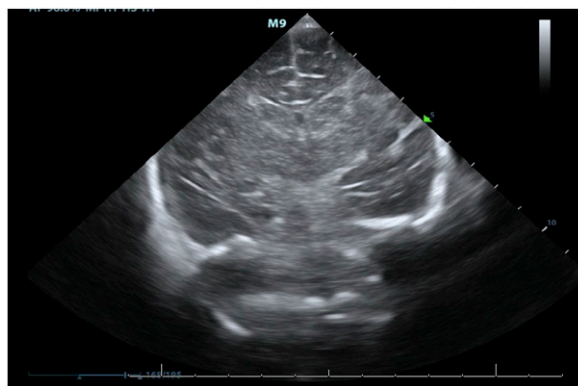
Cranial ultrasonographic scan showing a partially effaced ventricle as well as cerebrospinal fluid spaces that denote the possibility of brain edema.
